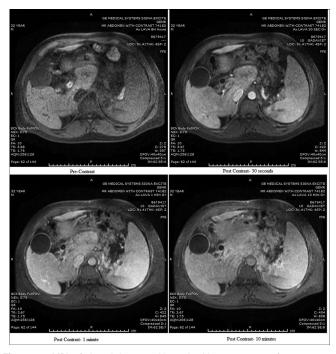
MRI of the abdomen with and without contrast after treatment showing improvement of the caudate lobe infarct.
